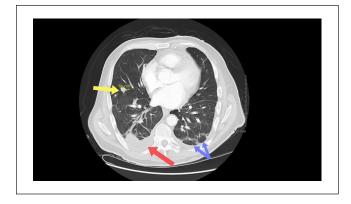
Chest computed tomography showing multiple pulmonary nodules, septic emboli measuring 14 mm (yellow arrow) with feeding vessel sign, right-sided pleural effusion (red arrow), and left-sided subpleural wedge-shaped densities without necrosis (blue arrows).
